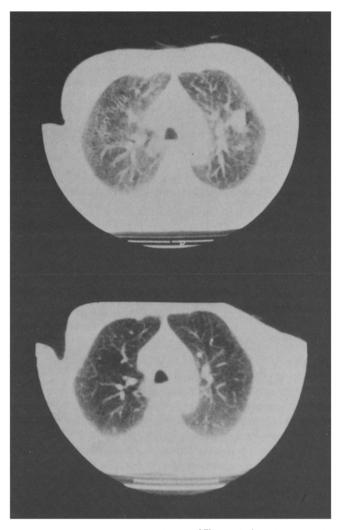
Pulmonary complete remission (CT scan before therapy and after the fourth maintenance cycle).
